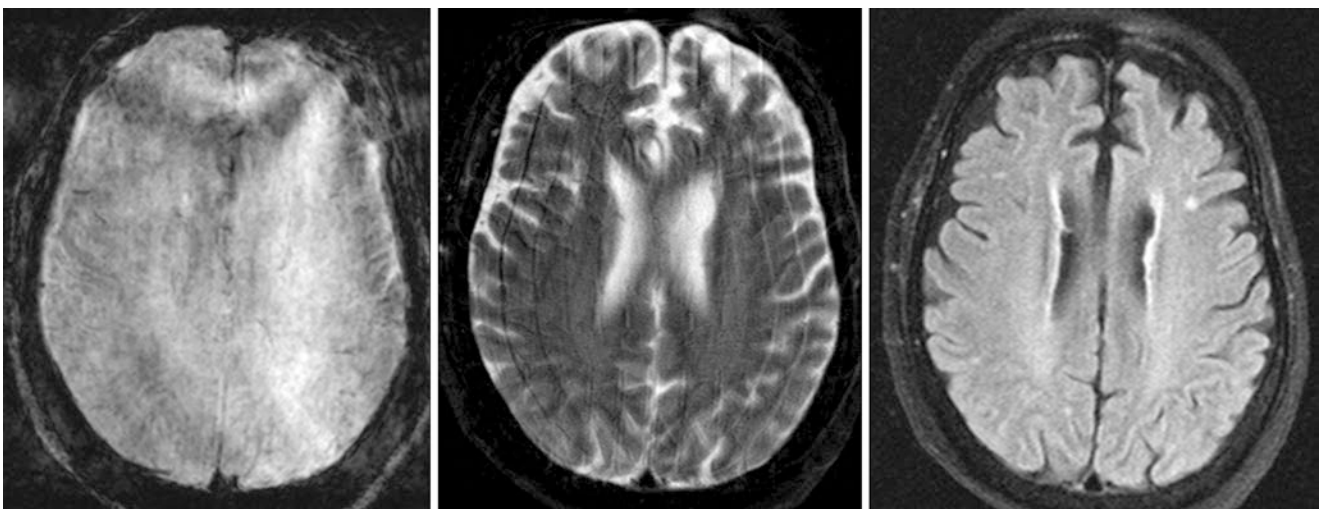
Motion-related artifact. A 64 year old with moderate-severe artifact from motion on 2-mm-thick (left) and on SE T2WI (middle) SWI at 1.5T. The artifact is hazy and obscures the normally dark veins (deoxygenated blood). FLAIR (right) was not affected
